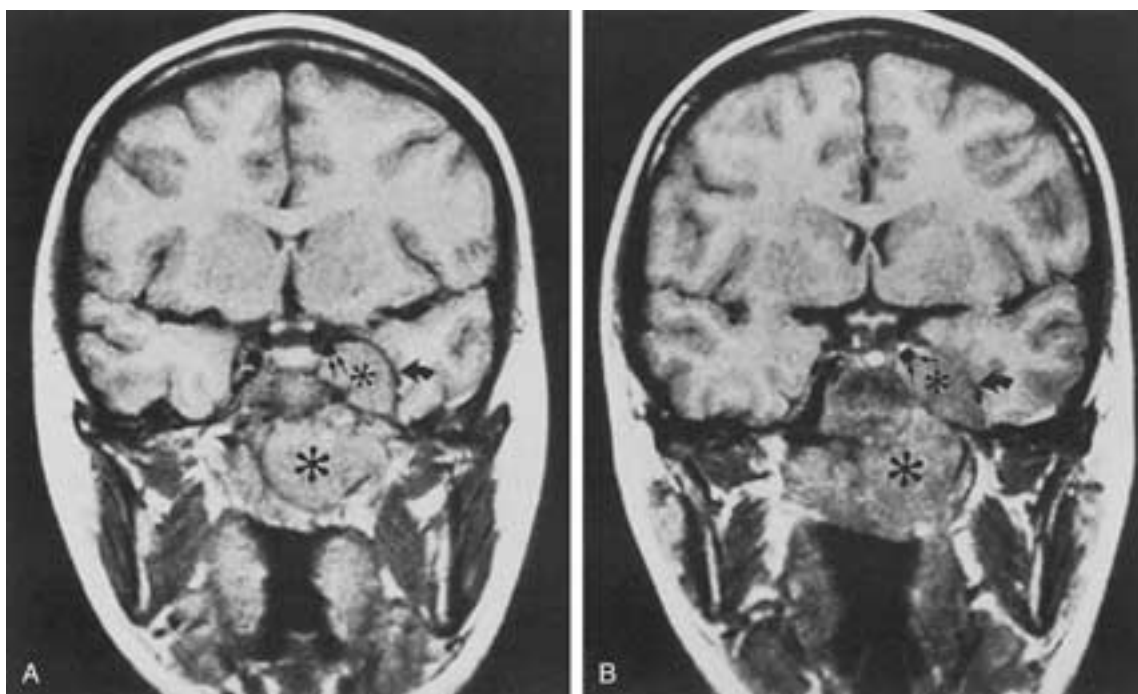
A 12-year-old male presents with restriction of ocular motion and nasal stuffiness. Rhabdomyosarcoma of the nasopharynx with extension through the skull base. Coronal T1-weighted image shows the presence of a mass within the nasopharynx (*large asterisk*), with skull base destruction and invasion of the left cavernous sinus (*small asterisk*). Note the lateral deviation of the lateral dural reflection of the cavernous sinus (*curved arrow*). The mass abuts the cavernous internal carotid artery (*small arrows*). (From Braun IF. MRI of the nasopharynx. *Radiol Clin North Am* 1989;27(2):315.)
